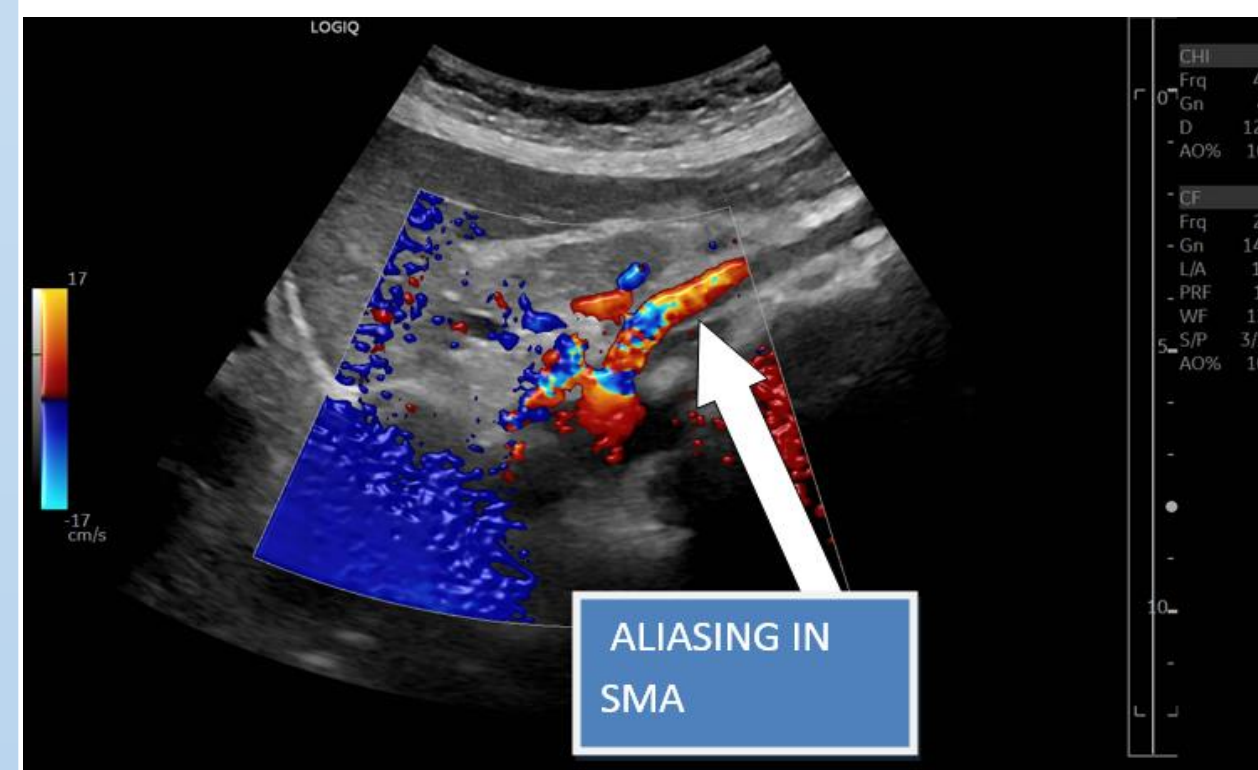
Patent superior mesenteric artery on Colour Doppler with aliasing indicating high flow
